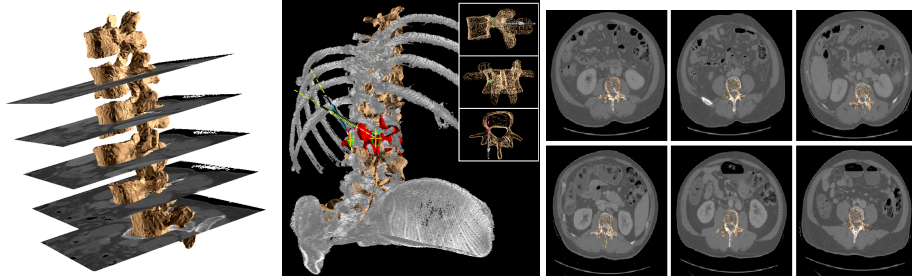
Visual inspection of registration results. From left to right. Global alignment of preop model with CT images. Fused 3D model for guidance of pedicle screw insertion. Series of CT slices with corresponding geometrical vertebral models.
